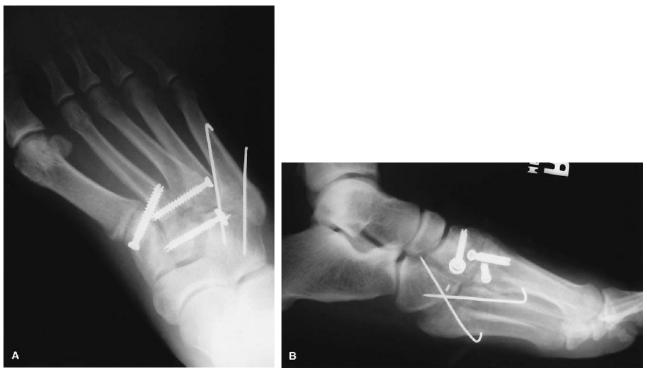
(A, B) Anteroposterior (A) and lateral (B) postoperative radiographs. A 4.5-mm cannulated "Lisfranc" screw stabilizes the medial cuneiform to the second metatarsal. The intertarsal dislocation is reduced and stabilized with a 4.0-mm cannulated screw and washer, and the third tarsometatarsal fracture–dislocation is reduced and stabilized with a 4.0-mm cannulated screw from the third to the second metatarsal bases. The cuboid is reduced and stabilized to the reduced fourth and fifth tarsometatarsal joints with 0.062-in. K-wires.
